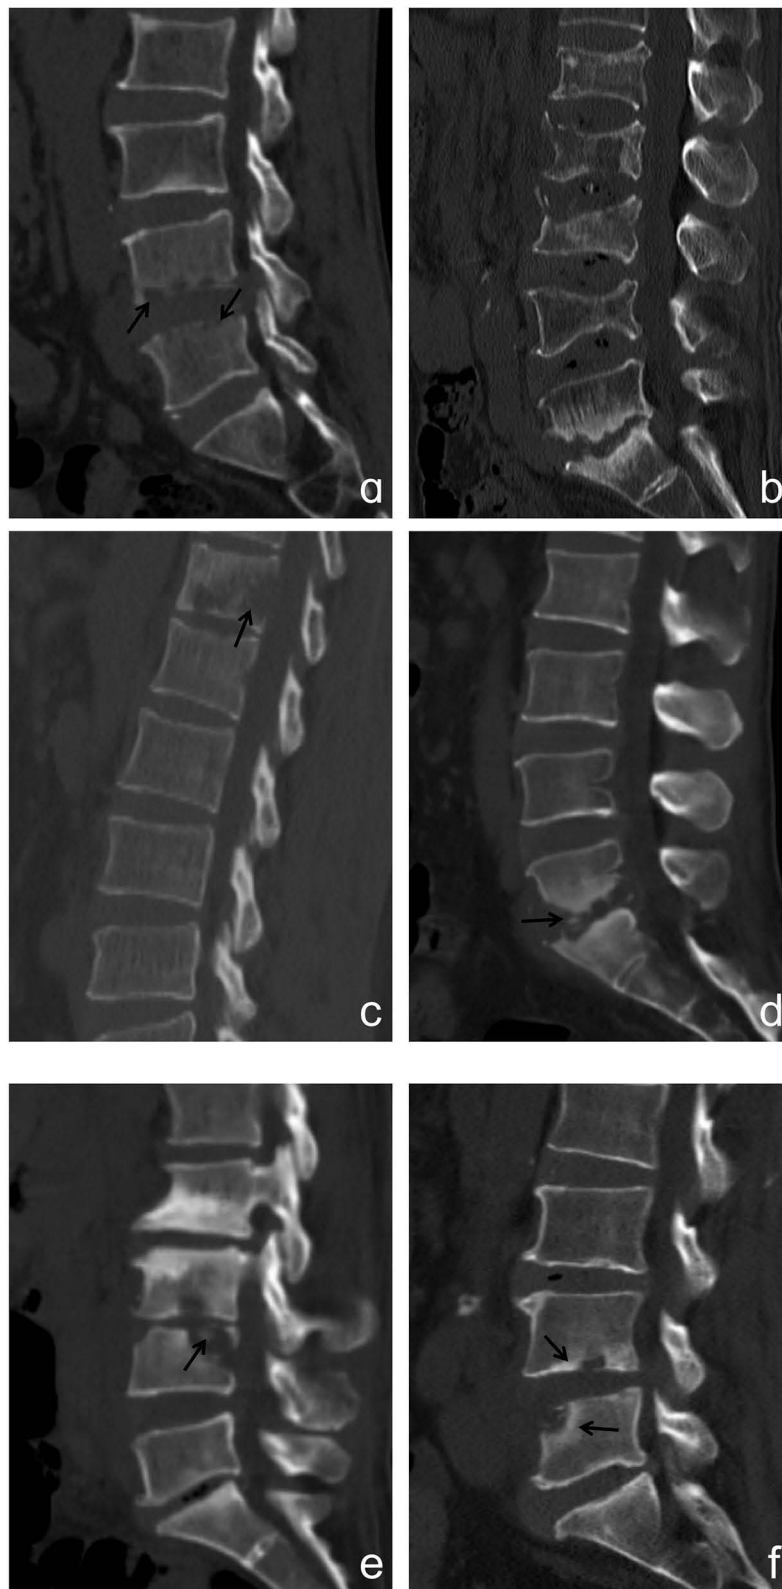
(a) CT scan with sagittal reconstruction of fungal spondylitis shows single segment involvement of bone destruction, worm eaten-like bone destruction beneath the L4-5 vertebral plates, no obvious intervertebral stenosis, and no osteosclerosis around the bone destruction (black arrow); (b) CT scan with sagittal reconstruction of brucellar spondylitis shows multiple segment involvement of bone destruction; (c) CT scan with sagittal reconstruction of fungal spondylitis shows bone destruction centered on the vertebral body at L1, and no osteosclerosis around the bone destruction (black arrow); (d) CT scan with sagittal reconstruction of brucellar spondylitis shows bone destruction centered on the intervertebral disc at L5 and S1, and osteosclerosis around the bone destruction (black arrow); (e) CT scan with sagittal reconstruction of brucellar spondylitis shows bone destruction at L3-4, punctate sequestration inside the bone destruction (black arrow), and no osteosclerosis around the bone destruction; (f) CT scan with sagittal reconstruction of brucellar spondylitis shows bone destruction at L4-5, and osteosclerosis around the bone destruction.
